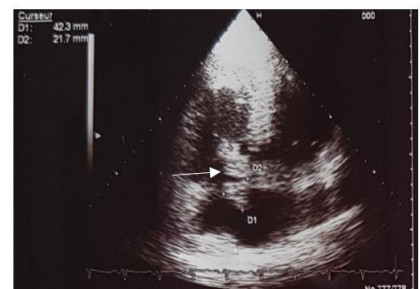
Follow up two-dimensional transthoracic echocardiography at the second week with no findings of intra-cavitary thrombus
